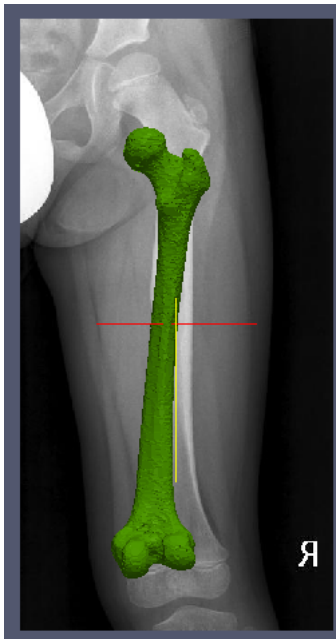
Generic model after ICP algorithm and patient's radiographic image
